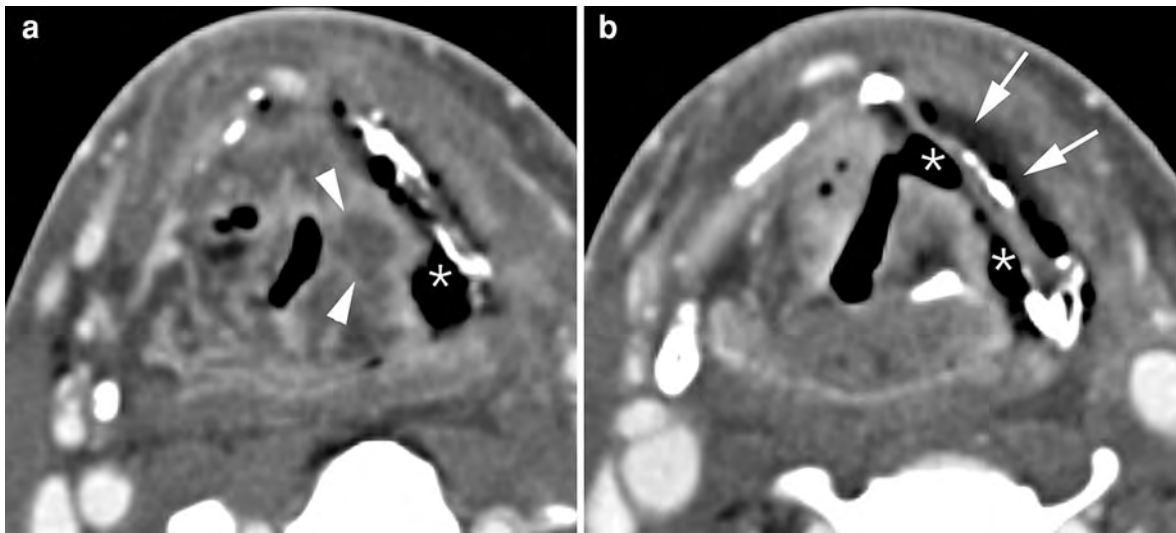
Axial contrast-enhanced CT-images. Patient treated five months earlier by irradiation for T3 supraglottic cancer, suffering from progressive dysphagia. Laryngoscopy showed a fixed left vocal cord, suspect for tumor recurrence. a On a background of expected changes after radiation therapy, a centrally hypodense nodular area of soft tissue thickening is seen in the left aryepiglottic fold (*arrowheads*). Furthermore, a large soft tissue defect (*asterisk*), connecting the left piriform sinus with the denuded thyroid cartilage lamina, is seen. The
